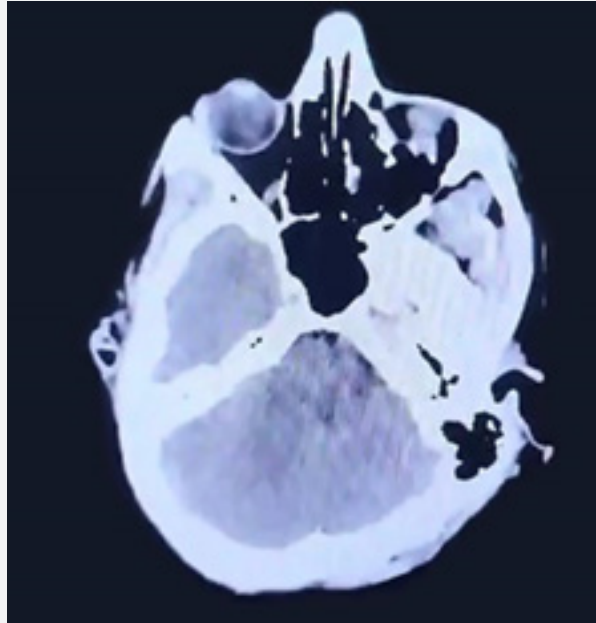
(A): Postoperative CT scan image showing penetrating site after removal of the foreign body.
